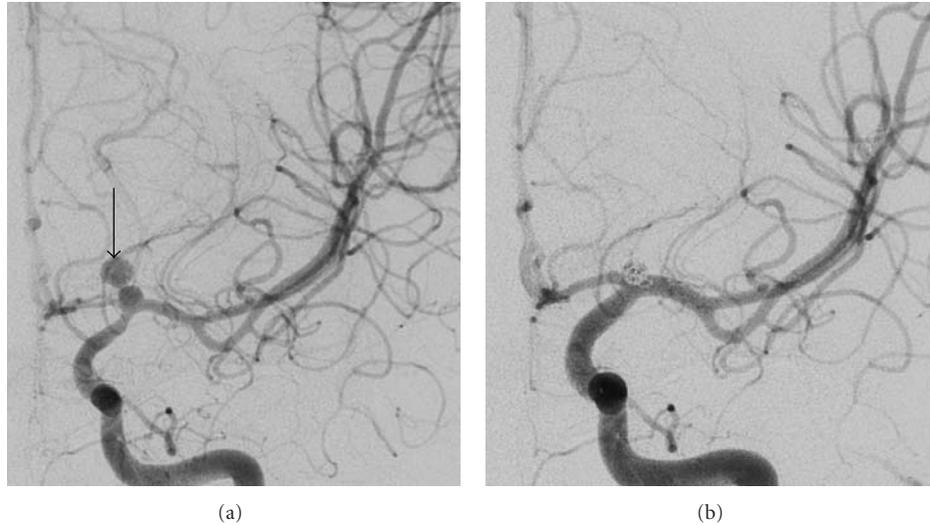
Anteroposterior view of the left internal carotid artery angiography shows a blister-like aneurysm at the intracranial bifurcation (a). Note the small pseudoaneurysm (arrow in (a)) at the dome of the aneurysmal sac, corresponding to the image seen on the CT (Figure 7), and the spasm in the supraclinoid portion of the carotid artery. The posttreatment angiography shows successful obliteration of the aneurysm with stent and a single platinum coil (b).
